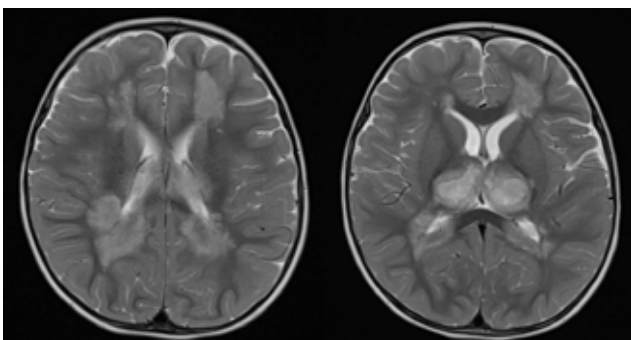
MRI findings of the endocranium of patient 4: massive lesions of the white matter of both hemispheres of the cerebrum and cerebellum, thalamus and brainstem
